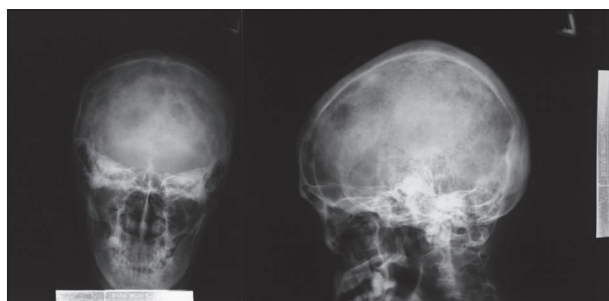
Radiography of the skull and spine with osteolytic metastases
